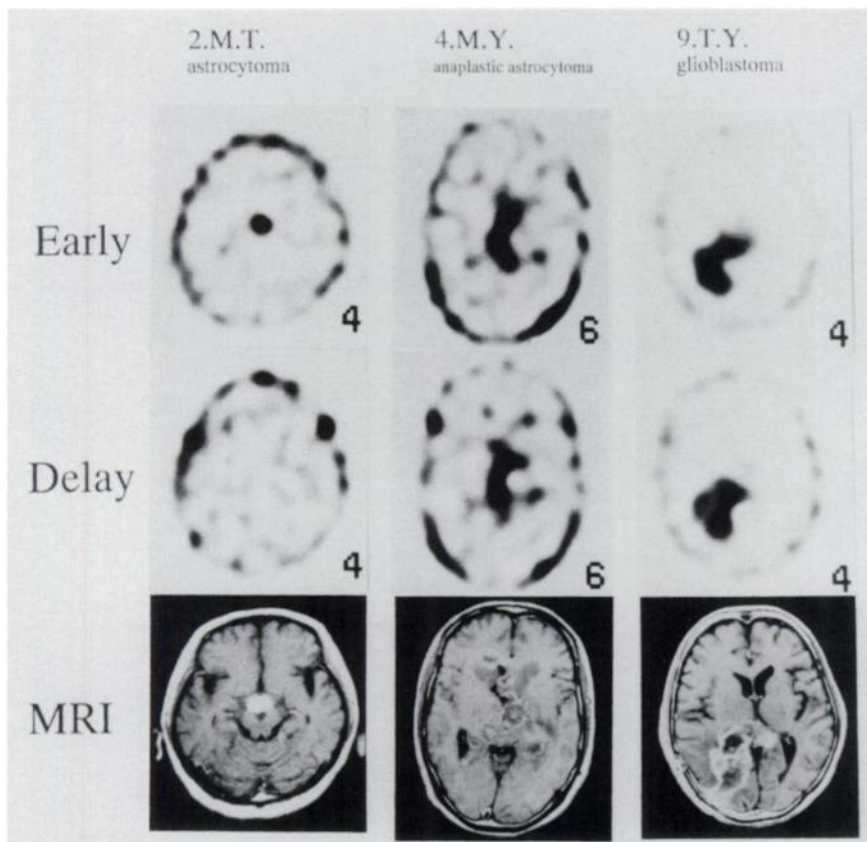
Typical ^{201}Tl SPECT images. From left to right: astrocytoma (Patient 2), anaplastic astrocytoma (Patient 4) and glioblastoma (Patient 9) are demonstrated. (Top) Thallium-201 early images, (middle) ^{201}Tl delayed images and (bottom) Gd-enhanced MR images.
